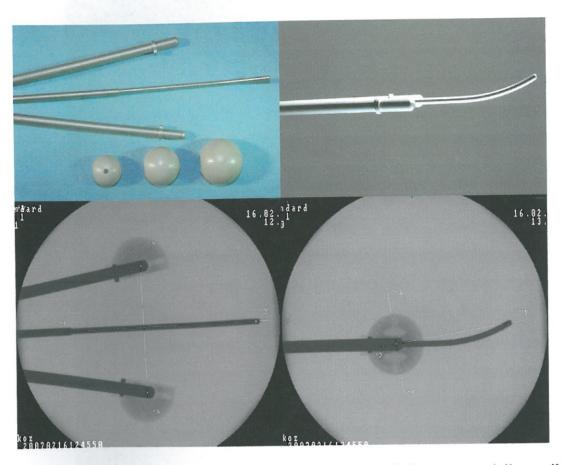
Image and an X-ray presentation for geometry of the commercially available applicators serving as basis for the treatment planning and dose distribution to the CTV and OARs. Different sizes of ovoid shields are also presented (explanation see in the text).
